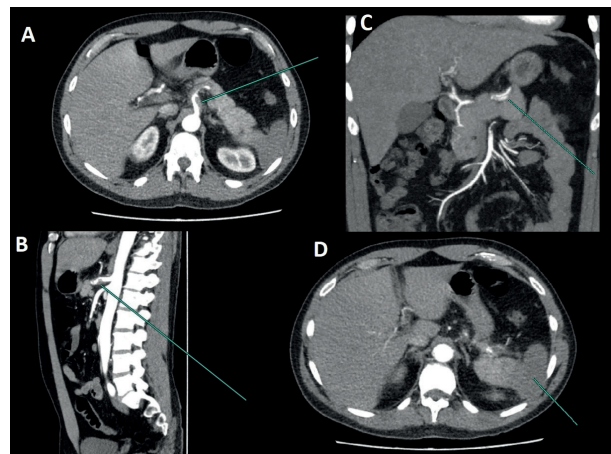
CT angiography of the Abdomen: (A) Thrombus in the Coeliac trunk in an Axial plane (B) Thrombus in the Coeliac trunk in a Sagittal plane (C) The splenic artery dissection (D) The splenic infarction in the lower lobe.
